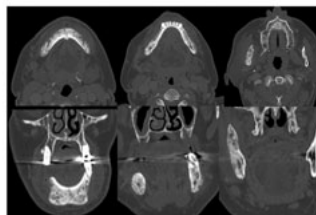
computed tomography with unchanged findings after antibiotic treatment and 10 sessions of hyperbaric oxygen therapy 06/2012.
